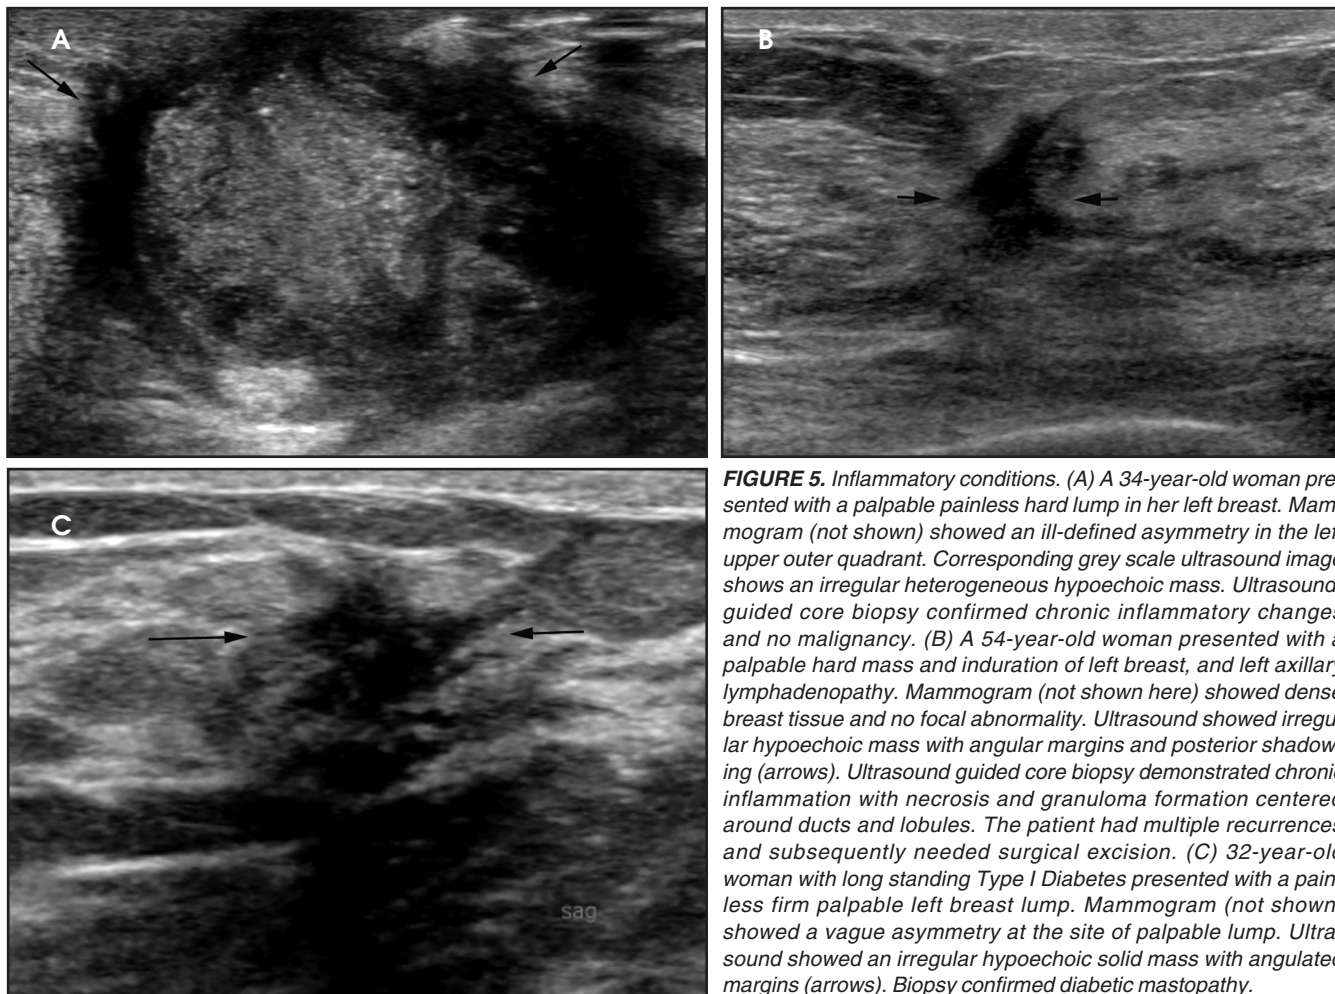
Inflammatory conditions. (A) A 34-year-old woman presented with a palpable painless hard lump in her left breast. Mammogram (not shown) showed an ill-defined asymmetry in the left upper outer quadrant. Corresponding grey scale ultrasound image shows an irregular heterogeneous hypoechoic mass. Ultrasound-guided core biopsy confirmed chronic inflammatory changes and no malignancy. (B) A 54-year-old woman presented with a palpable hard mass and induration of left breast, and left axillary lymphadenopathy. Mammogram (not shown here) showed dense breast tissue and no focal abnormality. Ultrasound showed irregular hypoechoic mass with angular margins and posterior shadowing (arrows). Ultrasound guided core biopsy demonstrated chronic inflammation with necrosis and granuloma formation centered around ducts and lobules. The patient had multiple recurrences and subsequently needed surgical excision. (C) 32-year-old woman with long standing Type I Diabetes presented with a painless firm palpable left breast lump. Mammogram (not shown) showed a vague asymmetry at the site of palpable lump. Ultrasound showed an irregular hypoechoic solid mass with angulated margins (arrows). Biopsy confirmed diabetic mastopathy.
